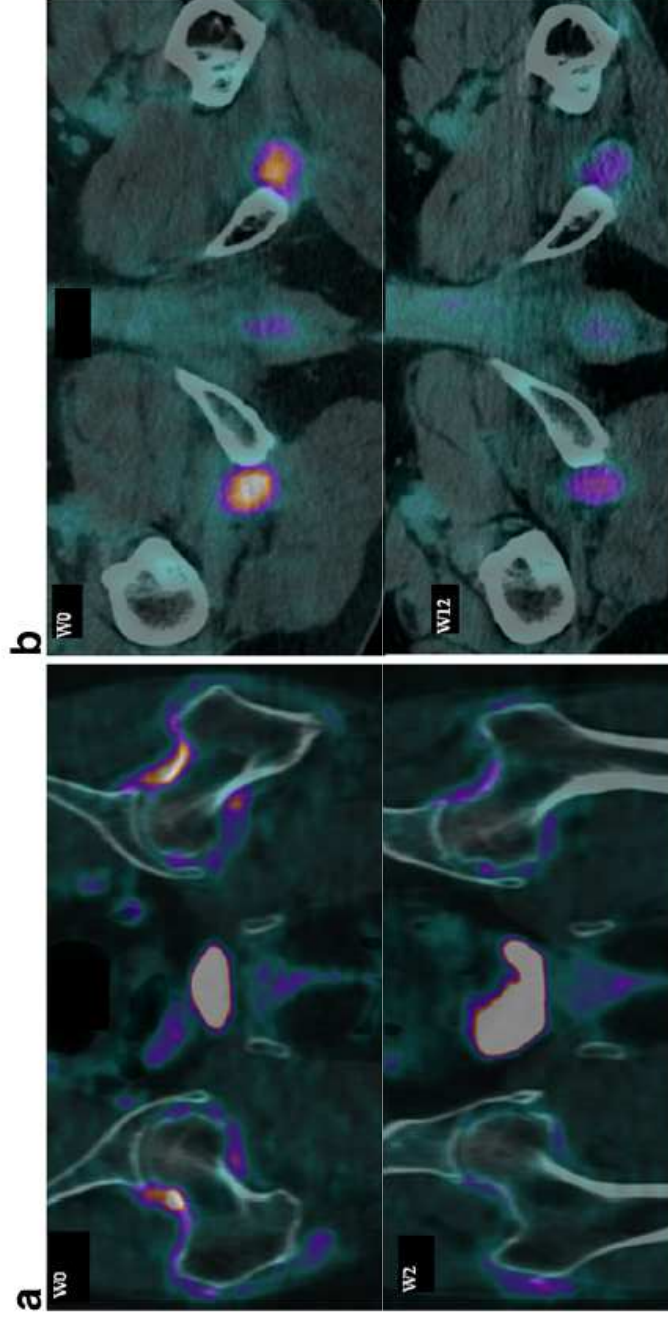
Changes in FDG uptake on follow-up PET/CT imaging. a Coronal images of the hip region before treatment (week 0, *W0*) and after one infusion of tocilizumab (week 2, *W2*) in a 73-year-old woman with polymyalgia rheumatica. At week 0, the right hip SUVmax is 12.3 and the left hip SUVmax is 9.7. At week 2, the right hip SUVmax is 10.1 and the left hip SUVmax is 9.4. b Axial images of the ischial tuberosity
